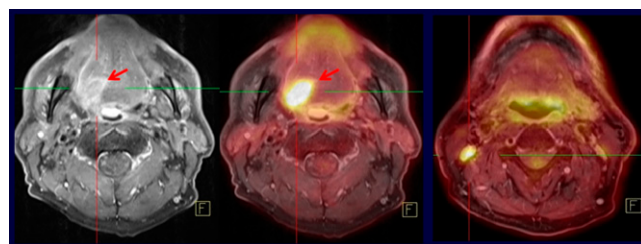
^{18}F -FDG PET/MR in a patient with head and neck cancer. Left to right: MR demonstrating tongue-based lesion, ^{18}F -FDG PET/MR fusion shows increased glucose metabolism in the lesion, fusion image at an additional level shows metabolic activity in a lymph node metastasis.
